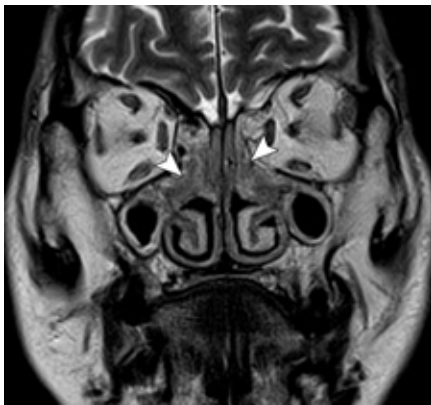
IgG4-related sclerosing sino-nasal disease: Coronal T2-weighted MR images demonstrate diffuse mucosal thickening of the nasal cavity and paranasal sinuses with low-signal-intensity infiltration (arrowheads).
